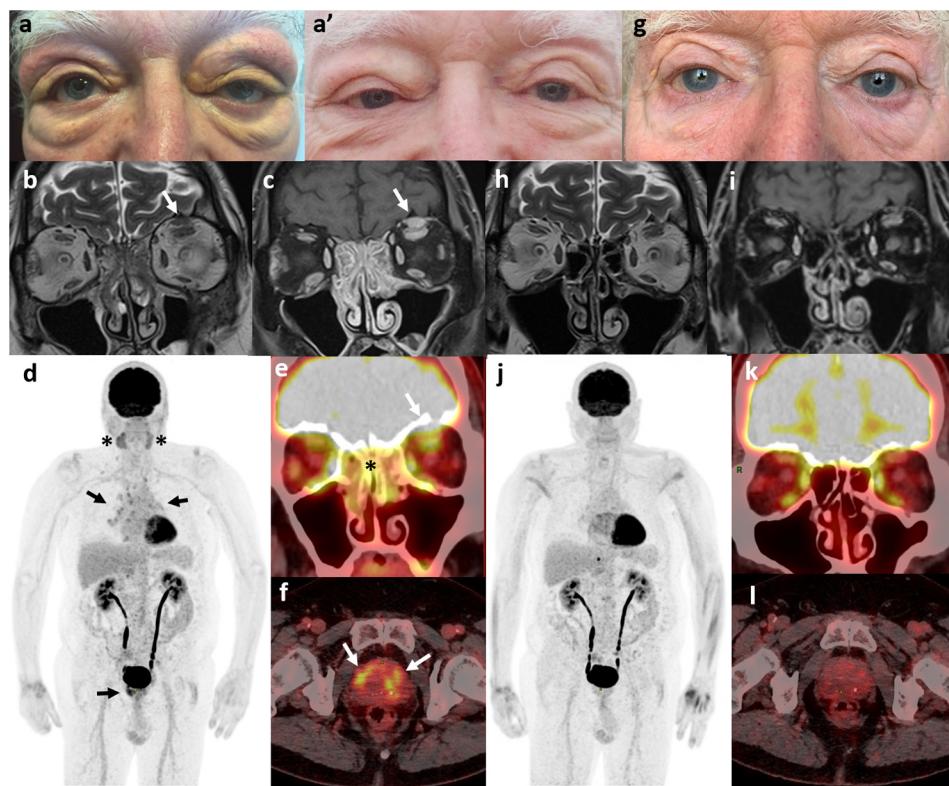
Clinical and morphological evaluation in-patient 2 before and after dupilumab administration. a: bilateral yellow swelling of the upper and lower eyelids in patient 2 prior to any treatment; a': Relapsing swelling of the eyelids in patient 2 before dupilumab; b and c, arrow: orbital MRI T2-weighted and Gadolinium-enhanced T1-weighted images with fat suppression prior to biotherapy revealed a gadolinium contrast enhancement of an extraconal mass surrounding the left superior rectus; d, e,f: FDG PET/CT evaluation shows intense FDG uptake foci at the top of the left orbit (Maximum Standard Uptake Value, SUVmax = not evaluable) (e, arrow) and an ethmoidal uptake (e, star) related to an extensive nasal polyposis (SUVmax 5.7), bilateral hypermetabolic sub-maxillary glands (SUVmax = 5.3); d, stars: bilateral hilar and mediastinal hypermetabolic lymphadenopathies (SUVmax = 4.7) (d, arrows), and a FDG uptake of the prostate (d and f, arrows) related to a biopsy-proven lymphoplasmacytic infiltrate (SUVmax = 9); h, i: after an 18 months dupilumab treatment; g: the periocular oedema fully regressed; h,i: orbital MRI showed the disappearance of all abnormalities; j, k, l: FDG PET/CT highlighted complete regression of all hypermetabolic lesions.
